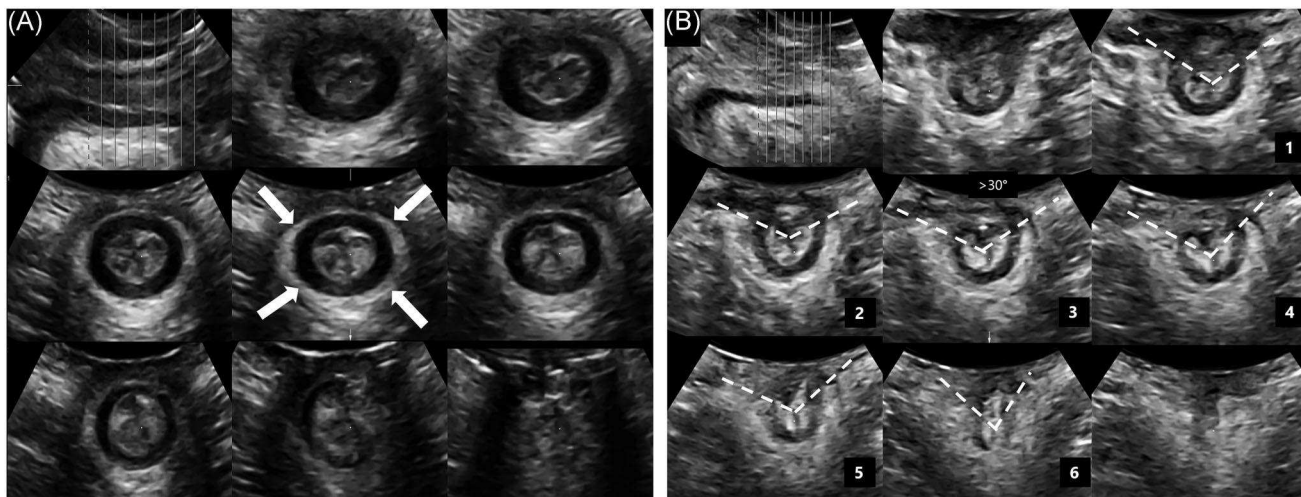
Three-dimensional transperineal ultrasound with tomographic ultrasound imaging showing (A) intact external anal sphincter (EAS) as a continuous hyperechogenic ring (white arrows) and (B) EAS defect, with the latter two showing a break (between dotted lines) in the echogenicity of involving $>30^\circ$ of the circumference in six of six images
